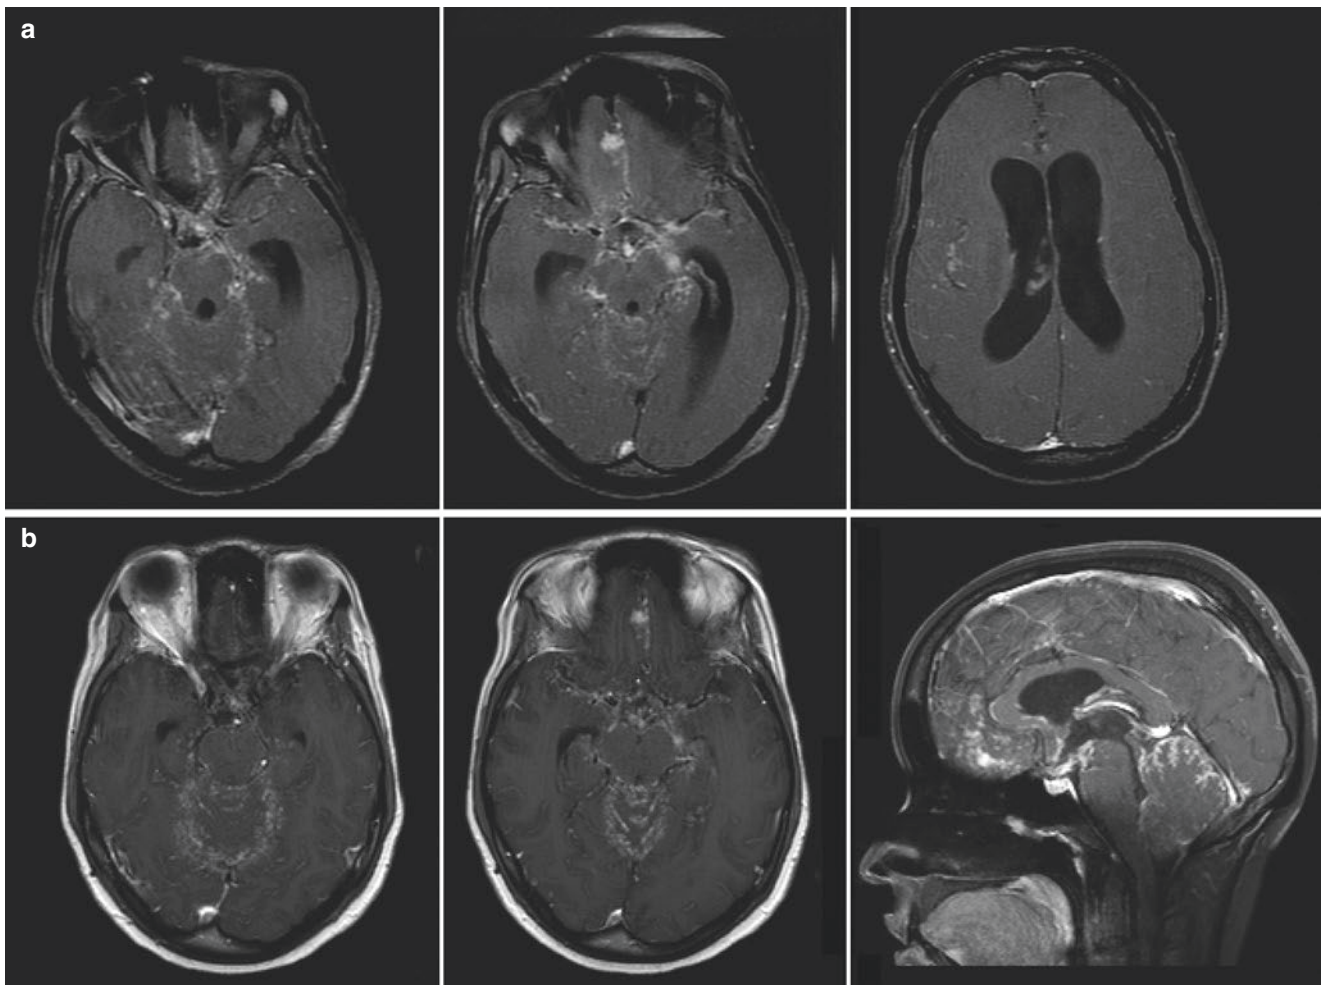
Brain magnetic resonance imaging (MRI) from the 32-year-old woman described in the case presentation in the text. (a) Axial T1-weighted images after administration of gadolinium contrast demonstrated ventriculomegaly and nodular leptomeningeal enhancement around the orbitofrontal meninges, midbrain, pons, and cerebellum. (b)
